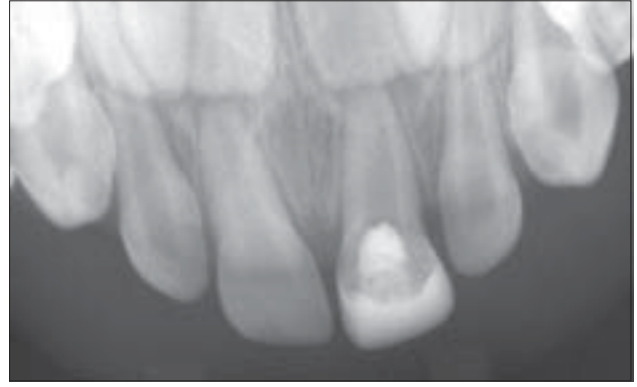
Radiograph exposed 18 months after treatment. Although it appears that development of the pulpotomized tooth has stopped, no pathosis or periapical areas are present.
